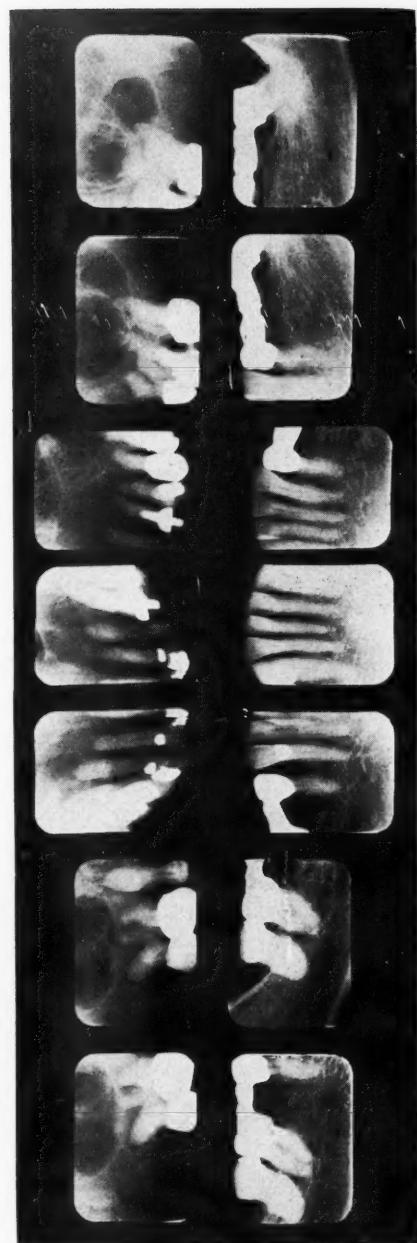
Intraoperative roentgenograms showing chronic osteomyelitis of maxilla involving all the teeth.
